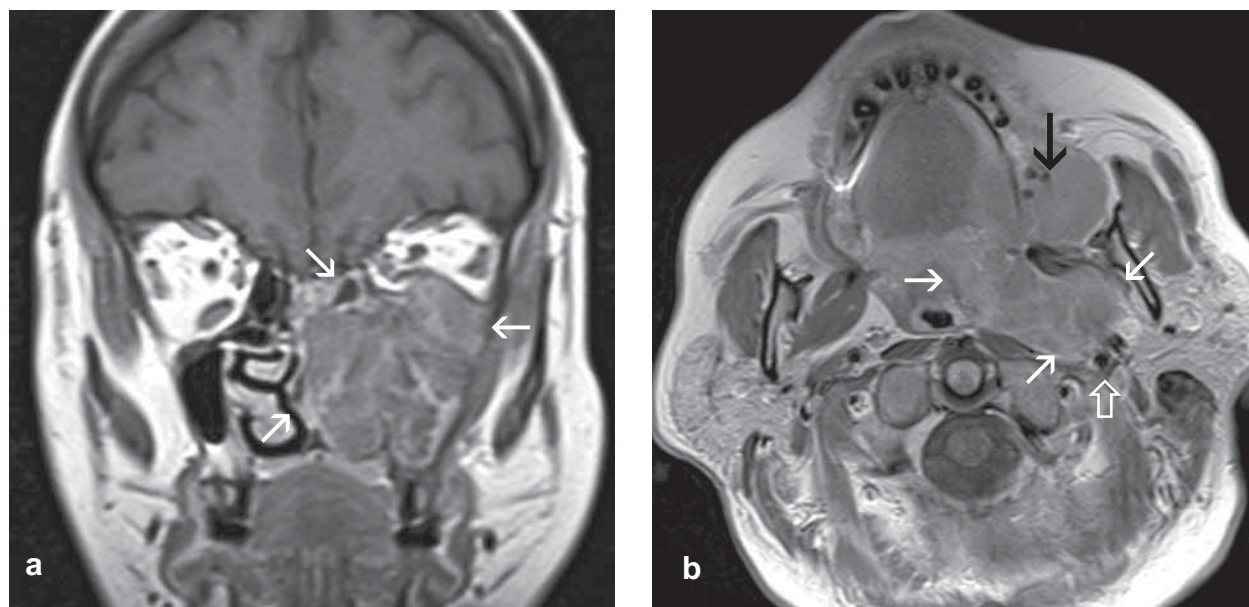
Squamous cell carcinoma of the maxillary sinus: (a) coronal contrast-enhanced T1-weighted image showing tumor extension to the left nasal fossa, ethmoid cells and intraorbital propagation with dislocation of inferior orbicular muscle and optic nerve (white arrows); (b) axial contrast-enhanced T1-weighted image shows suppressed of carotid arteries due to tumor propagation to the carotid space (empty white arrow). The tumor spread to the buccal, parapharyngeal and pharyngeal spaces and pterygopalatine fossa (white arrows), and to bone structure of the maxilla and hard palate (black arrow).
